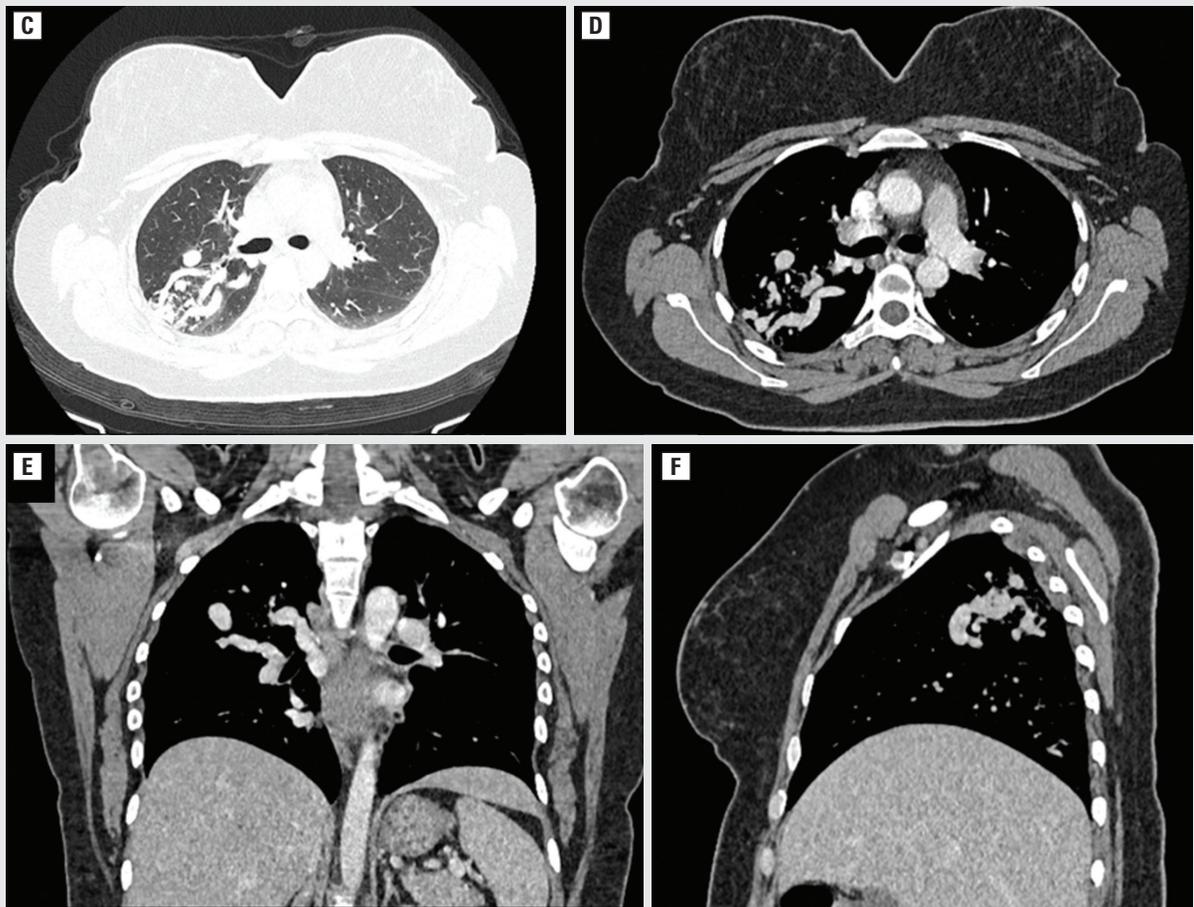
C. Axial chest computed tomography (CT) pulmonary window showing tubular branching opacities in the posterior segment of the right upper lobe. D. Axial CT mediastinal window showing a tuft of vessels. E. Coronal CT showing a pulmonary AVM with a feeding artery and draining vein. F. Sagittal CT showing a pulmonary AVM
